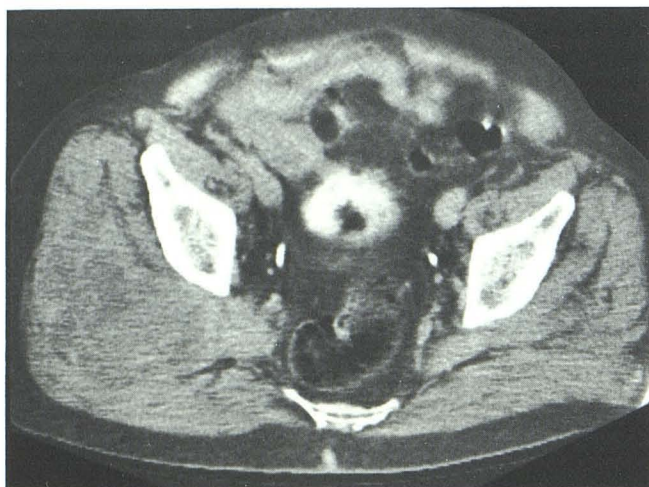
Case 19: severe pain in right leg in melanoma patient. CT demonstrates huge mass involving right gluteal muscles and extending into GSF.
